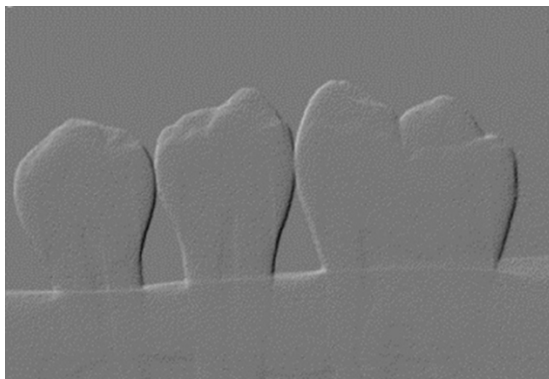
Application of the Emboss enhancement filter on the radiographs of the teeth
